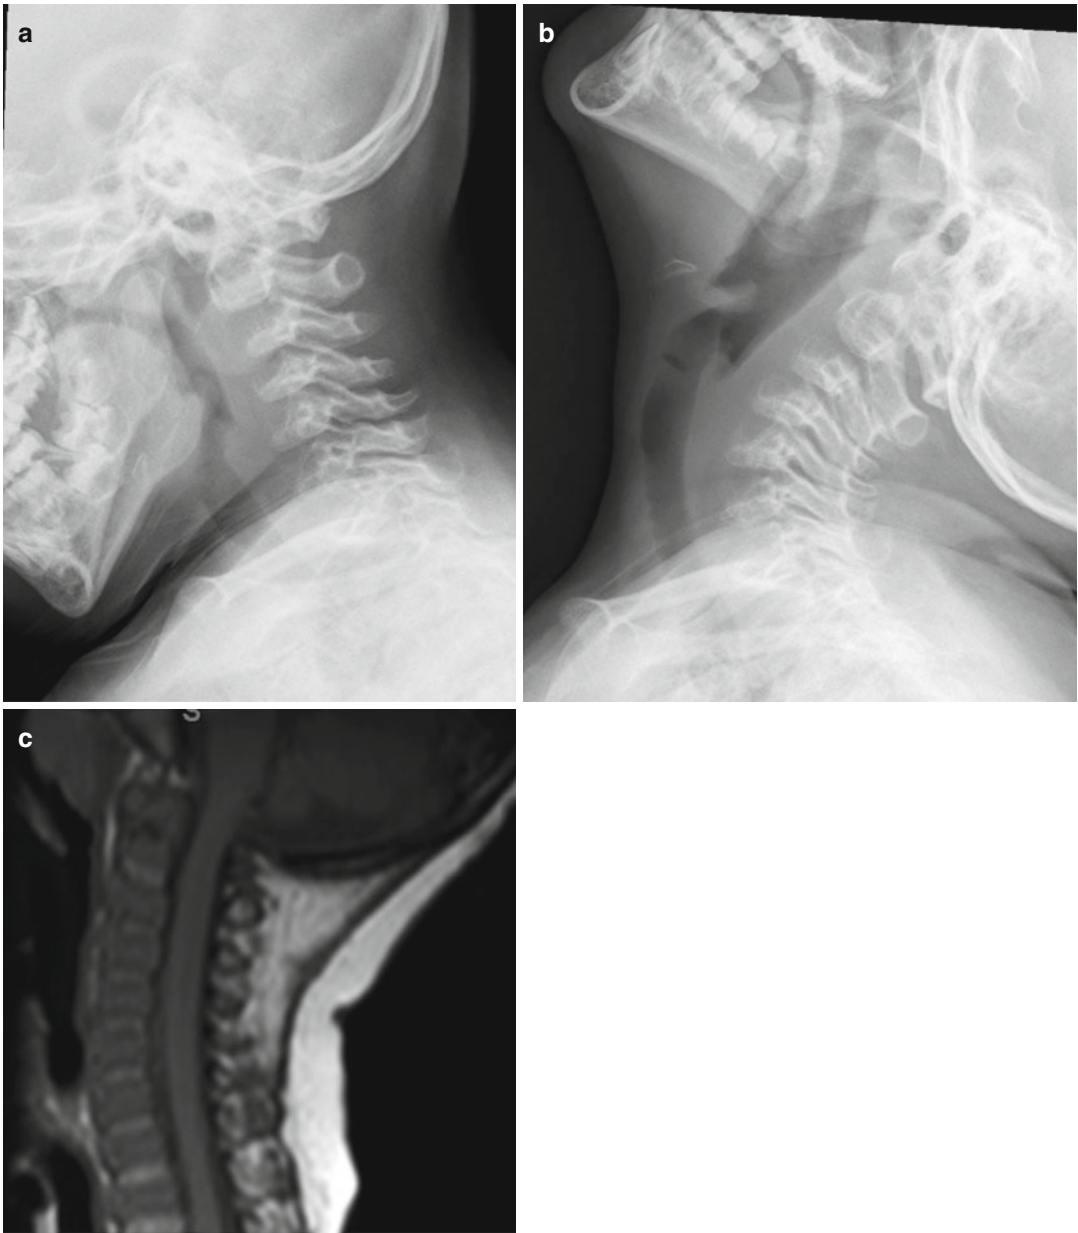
Lateral cervical radiographs showing C1–C2 cervical instability in Morquio syndrome. SAC decreased in flexion (a) from extension (b). Extradural mass shown
